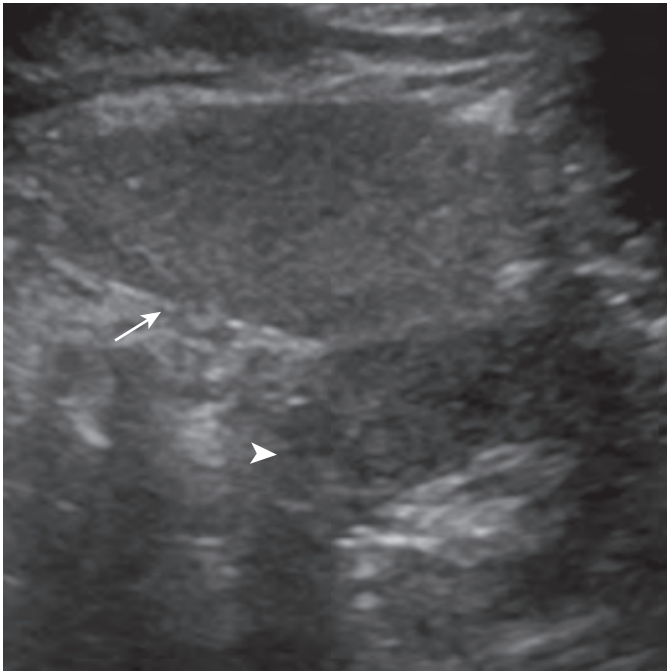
Normal spleen on ultrasound. Sonogram of a normal pediatric spleen demonstrates the normal uniform echotexture of the spleen (arrow) that is hyperechoic to the normal kidney (arrowhead).
